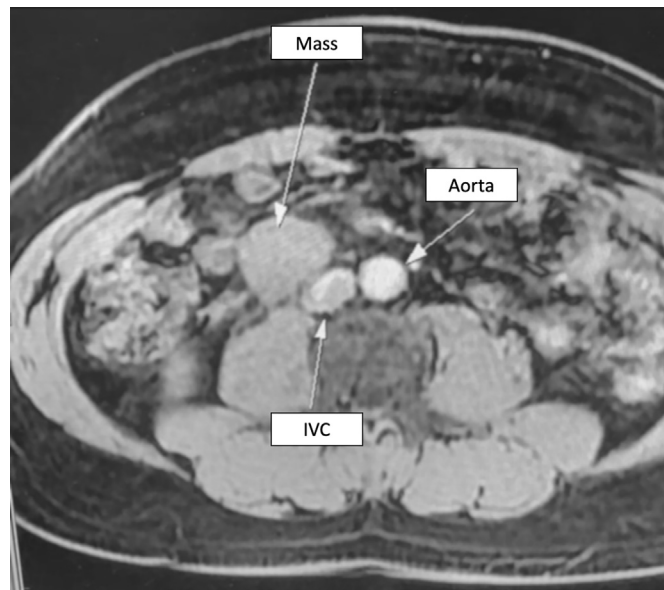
Sagittal plane of an MRI showing an adherent tumor to the inferior vena cava.
